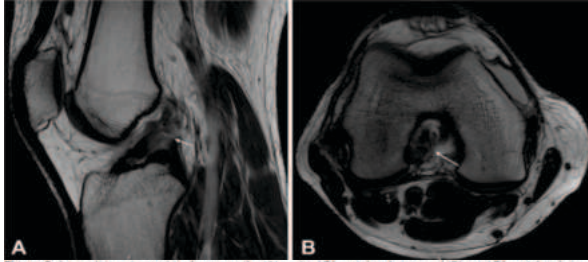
A type II tear (arrow) is shown on the (A) sagittal T1-weighted view and (B) axial T1-weighted view.
